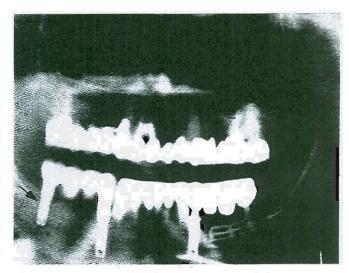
A panoramic radiograph shows a right mandibular posterior bridge with free-standing fixtures as abutments. When the mesial fixture's locking screw fractured, overloading and disintegration of the previously osseointegrated distal fixture occurred. The blade implant contralaterally replaced a fixture that also failed due to fracture of the mesial fixture's locking screw.
